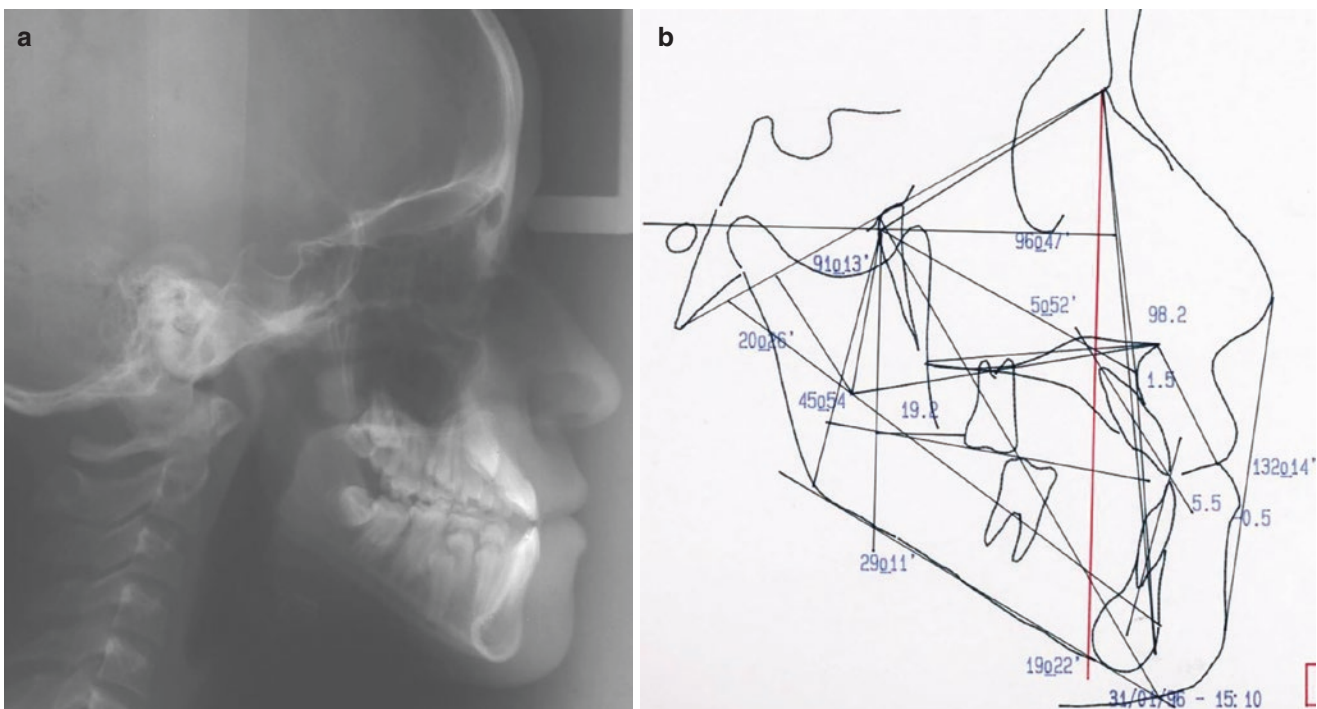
(a, b) Lateral radiographs and Ricketts cephalogram at the end of the Phase I of treatment. Most of the objectives were fulfilled
